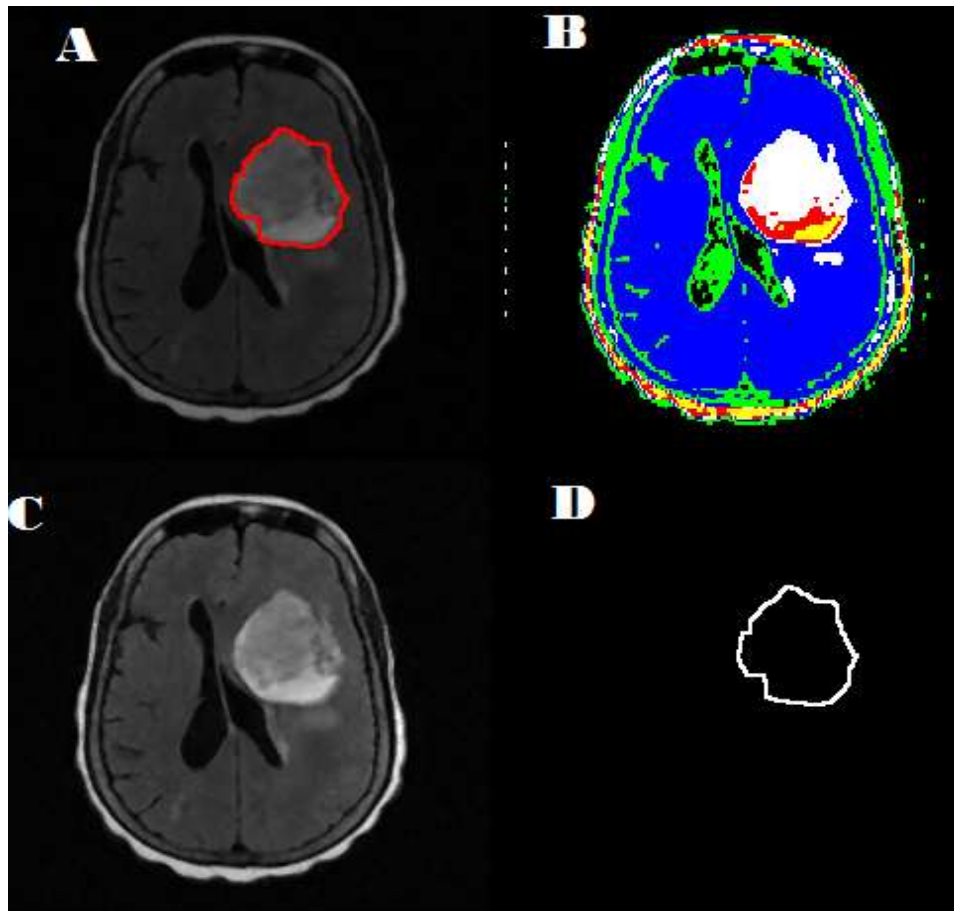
Demonstrate a heterogeneous brain mass [A] GTV definition based on tumor intensity profile, [B] Classification map based on intensity of brain tissue, [C] the original FLAIR image, [D] tumor margin drawn by algorithm generated IDL program that can be used as radiotherapy GTV.
